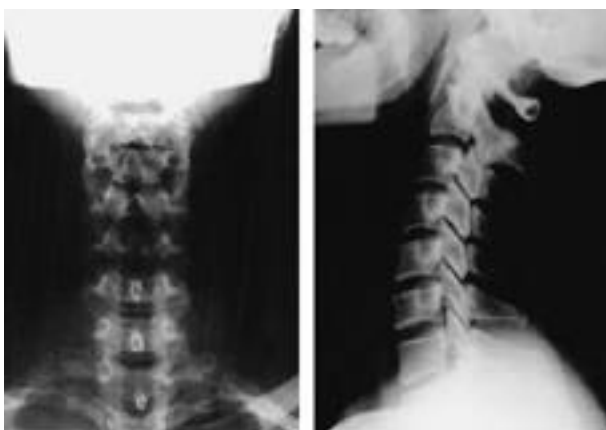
Anteroposterior and lateral roentgenograms of patient without cervical spine fracture and dislocation.
